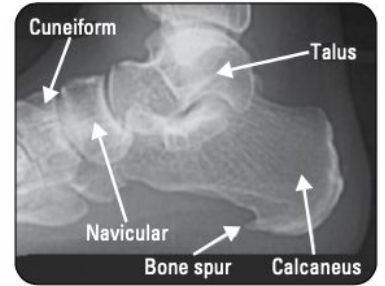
X-ray of bony heel spur
